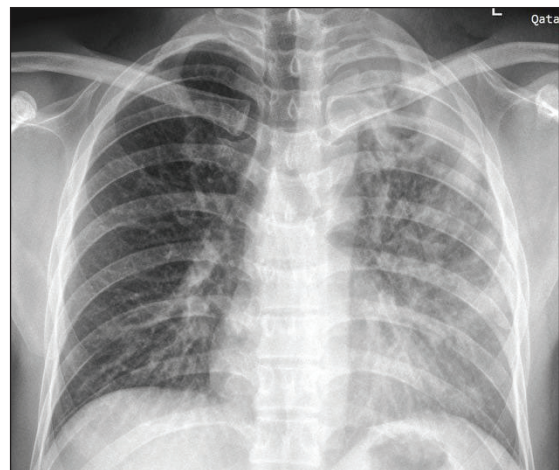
Chest X-Ray of a patient with pulmonary tuberculosis showing non-homogeneous opacity in the left lung with multiple cavitary lesions in the upper lobe of the left lung.
